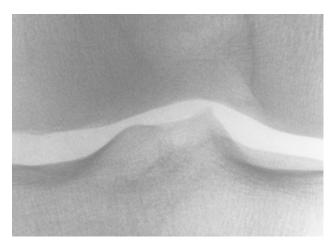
A sample joint center image used for the image analysis of the knee X-rays
